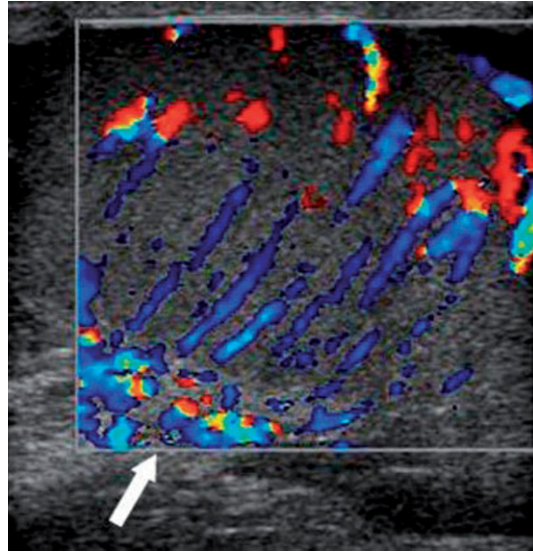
Color Doppler. The image shows the rich vasculature of the testicle with fan-shaped distribution. The *arrow* indicates the mediastinum testis
